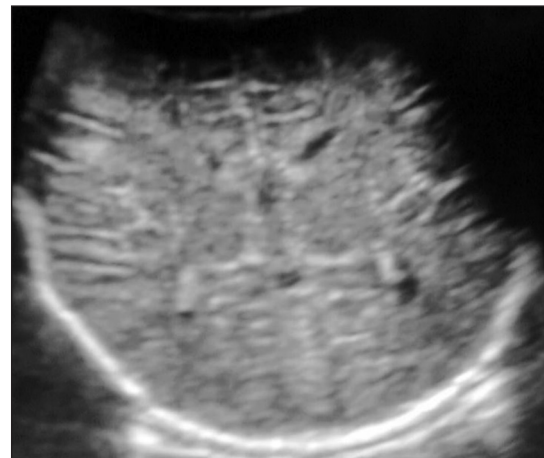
Brain sonography showing normal brain in a neonate
